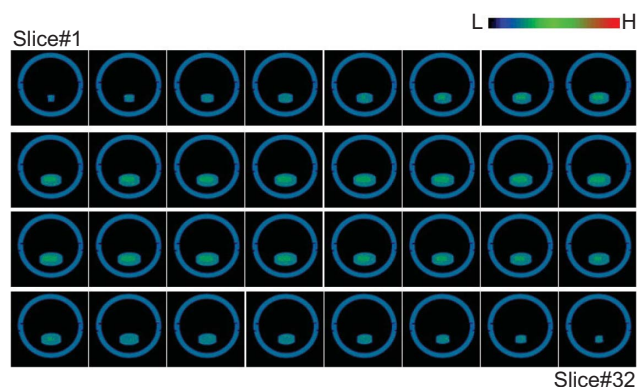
Image of internal structure of the press-coated tablet ["corporation A" (all slices)] using X-ray CT.
